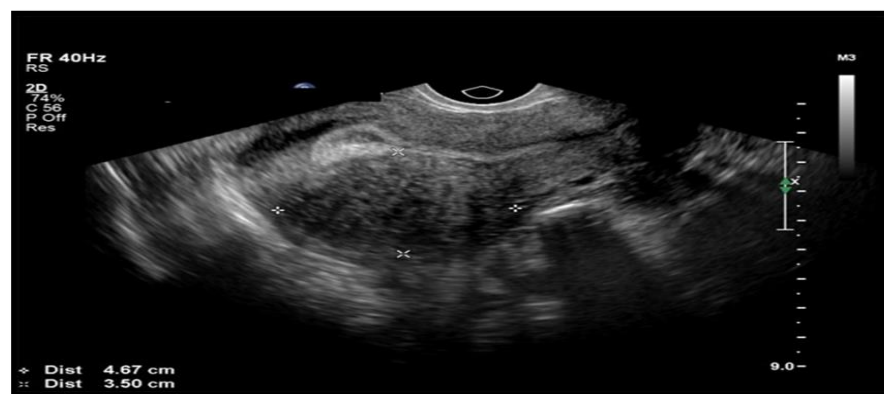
Transvaginal sonogram shows leiomyoma (between the markers) that extends from the serosa to the mucosa. [OBGYN.Net](http://OBGYN.Net)
